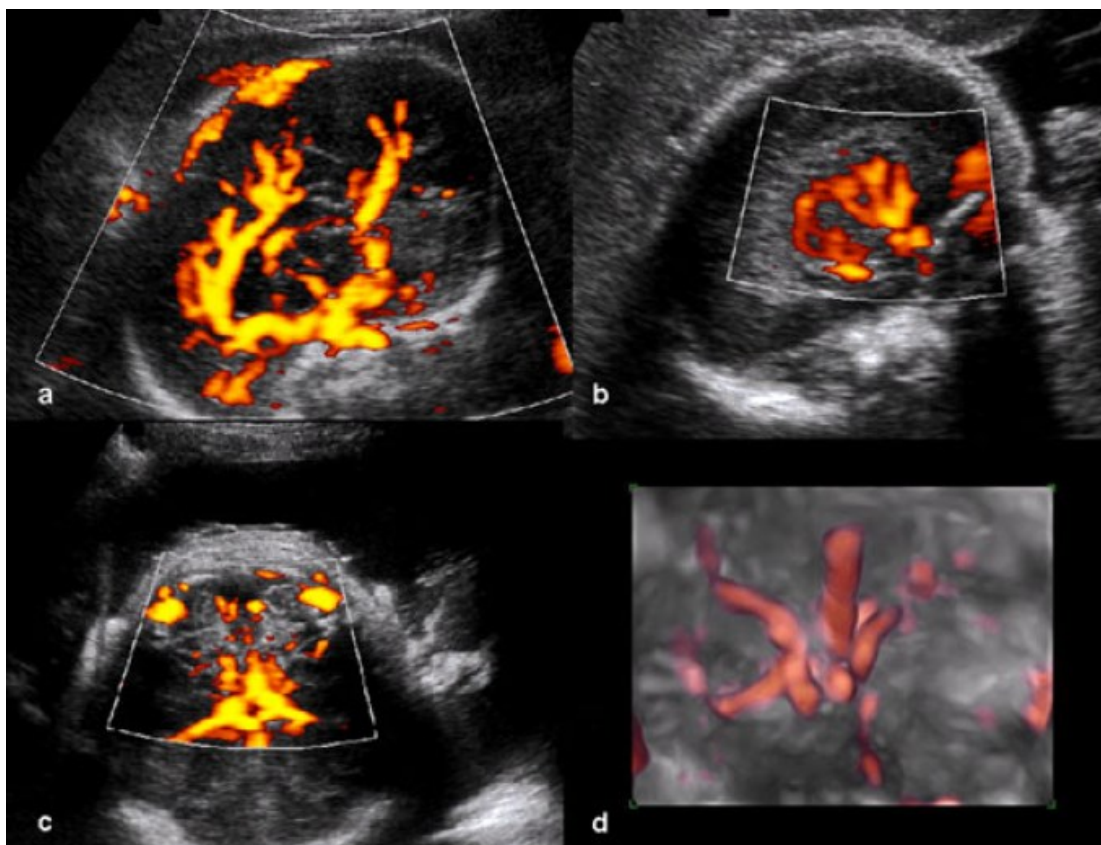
Power Doppler evaluation of the fetal brain. (a) Midsagittal view of the complete brain and frontal lobe; (b) Basal ganglia obtained in a parasagittal view; (c) posterior fossa in a transverse view with the fetus facing down; (d) 3D power Doppler render of the arterial circle of Willis.
